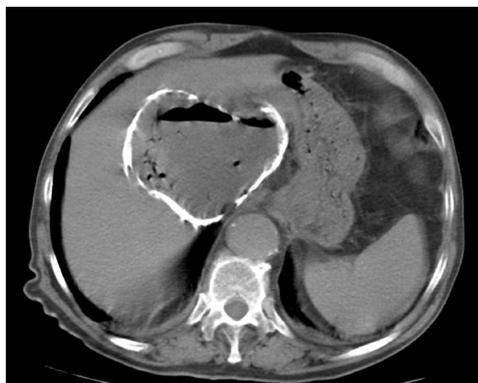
Abdominal computed tomography: Liver hydatid abscess.
